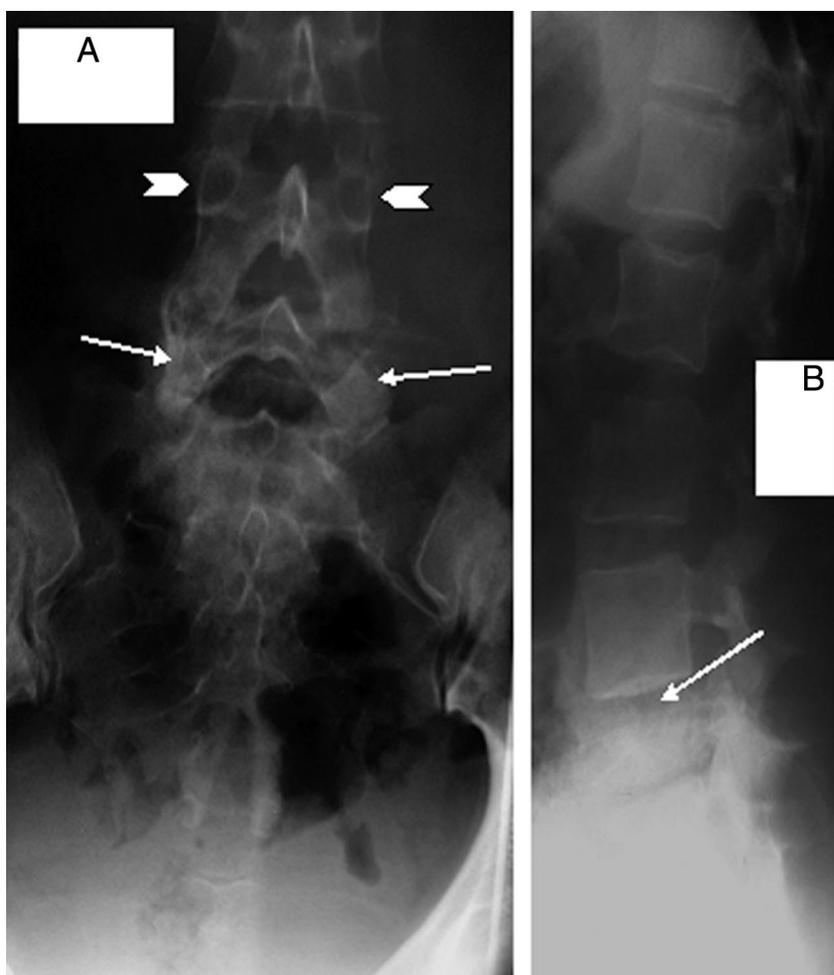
AP (A) and lateral (B) radiographs of the lumbar spine. The L5 vertebral body is sclerotic with ill-defined margins (arrow in B) and reduced height. Note that the pedicles of L5 in the AP view are dense and poorly defined (arrows in A). Compare with the normal pedicles of L4 (arrowheads). Pedicular sclerosis is a useful sign indicating vertebral metastases.
